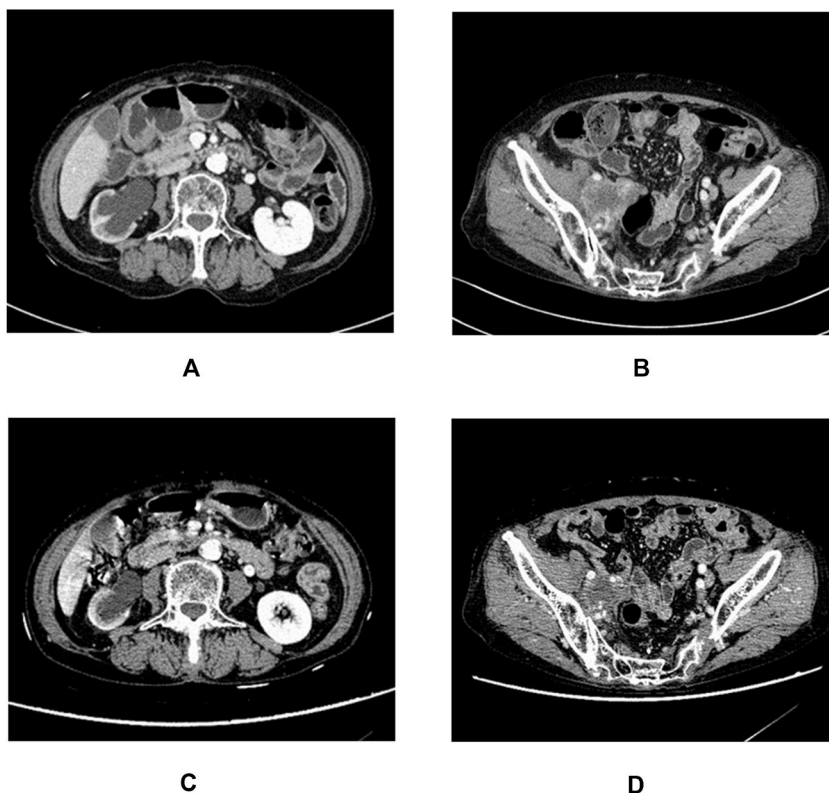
The CT scan of case 2. A&B. The middle and lower right ureter carcinoma with invasion to right iliac arteriovenous. C&D. The stable disease lesion after 5 cycles of camrelizumab plus apatinib and radiotherapy.
